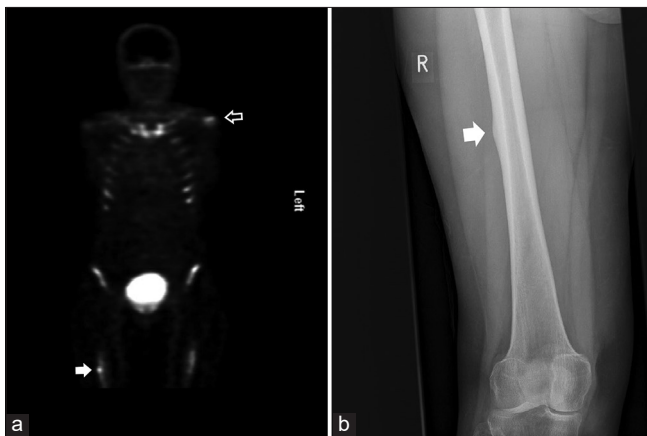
(a) A 58-year-old female had a bone scan with SPECT demonstrated avid uptake in the humerus consistent with known lytic lesion (empty white arrow) and avid focal uptake along the proximal right femur (solid white arrow). (b) Radiograph of the right femur demonstrates lateral cortical beaking along the mid-shaft of the right femur (solid white arrow). SPECT: Single-photon emission computer tomography.
